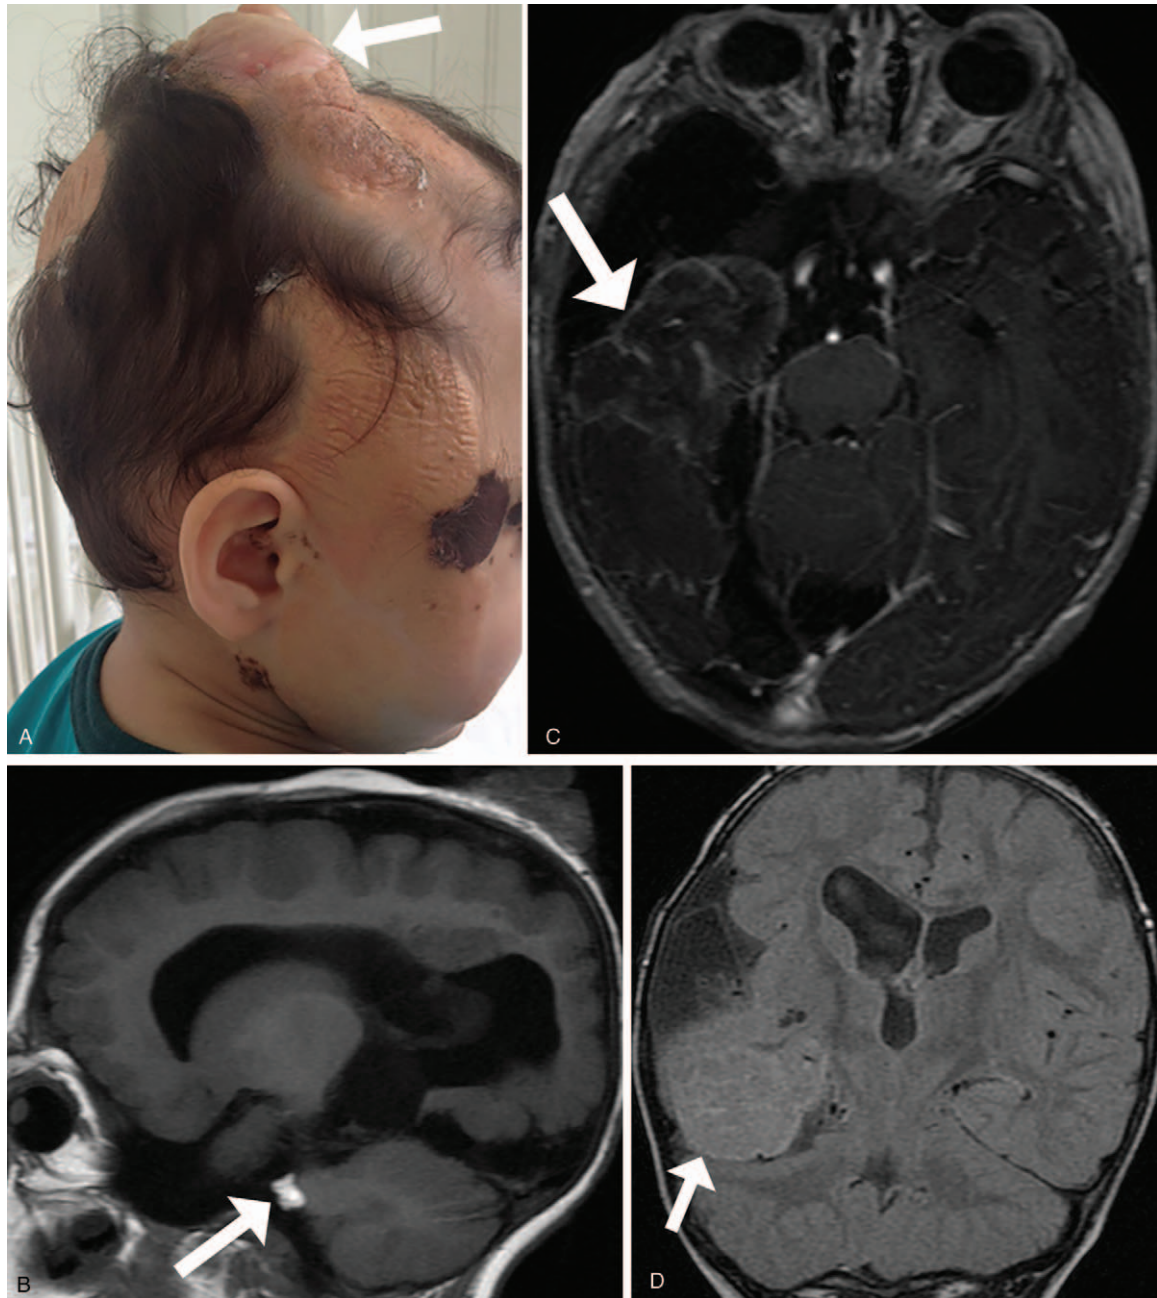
4-Year-old boy with encephalocraniocutaneous lipomatosis. Fatty tissue nevi, smoothly surfaced and hairless involving the scalp, compatible with nevus psiloliparus (white arrow on A). Sagittal unenhanced T1-weighted image (B) shows nodular hyperintense lesion in the right cerebellopontine angle compatible with intracranial lipoma (white arrow). Axial contrast-enhanced T1-weighted image (C) shows abnormal leptomeningeal enhancement in the right temporal lobe, compatible with leptomeningeal angiomas (white arrow). Coronal T2-FLAIR image (D) shows cortical thickening and blurring of the grey-white matter junction as well as parenchymal signal hyperintensity, compatible with cortical dysplasia (white arrow).
